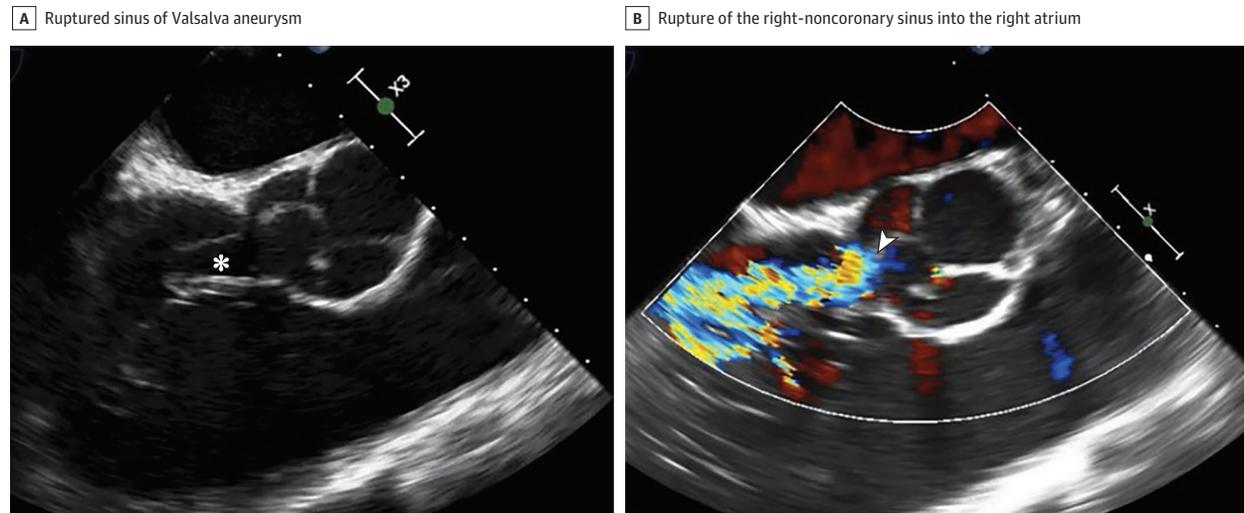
A, Sinus of Valsalva aneurysm with rupture into the right atrium. A transesophageal echocardiogram shows a ruptured sinus of Valsalva aneurysm (asterisk) in a young patient with a bicuspid aortic valve. B, Rupture of the right-noncoronary sinus into the right atrium created an aorto-right atrium fistula with a high-velocity flow (arrowhead).
